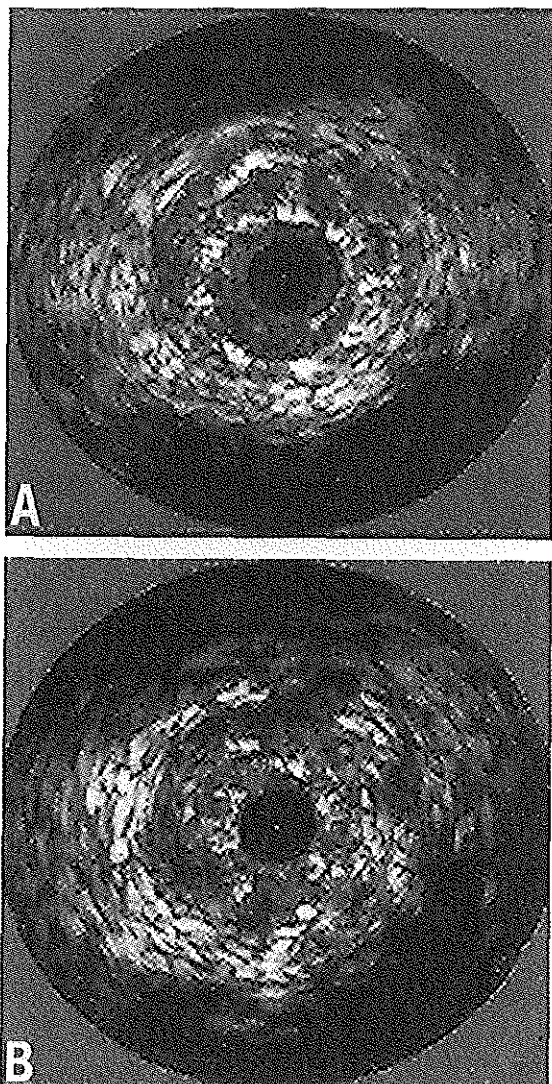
Intravascular ultrasound image of "pseudo in-stent restenosis" due to stent collapse. A=-in the stent, proximal to the stenosis, B=in the stent, at the site of the stenosis.
